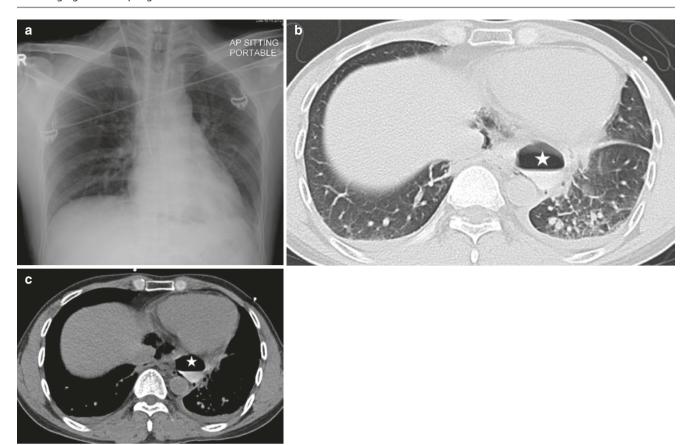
Boerhaave syndrome. (a) Frontal radiograph shows subtle lucencies beneath the cardiac shadow. (b, c) Axial CT images after swallowing a small cup of water-soluble contrast show air pockets
